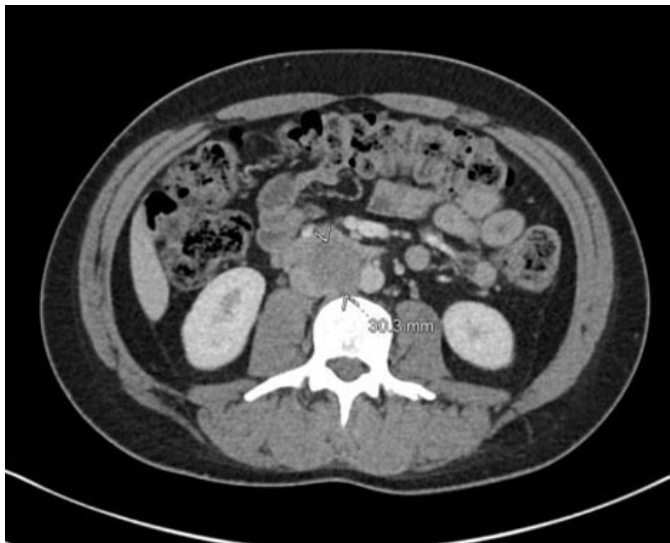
CT scan demonstrating 3 cm aortocaval node postoperatively and at the time of biochemical relapse.
